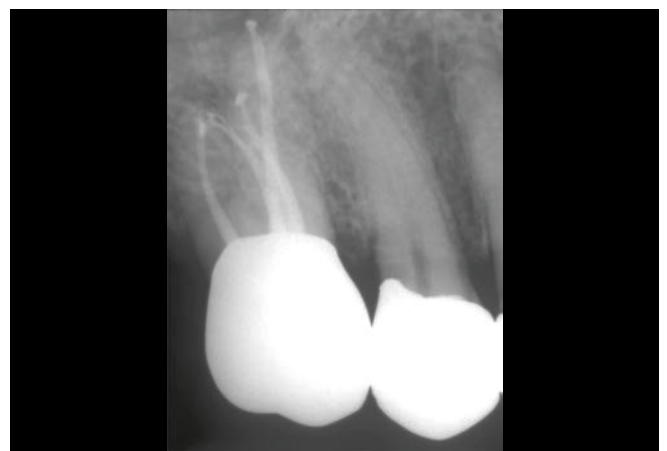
A radiograph reveals 4 filled systems. Specifically, note the deep MBI bifidity, the separate MBII system, and the provisionalized casting.
